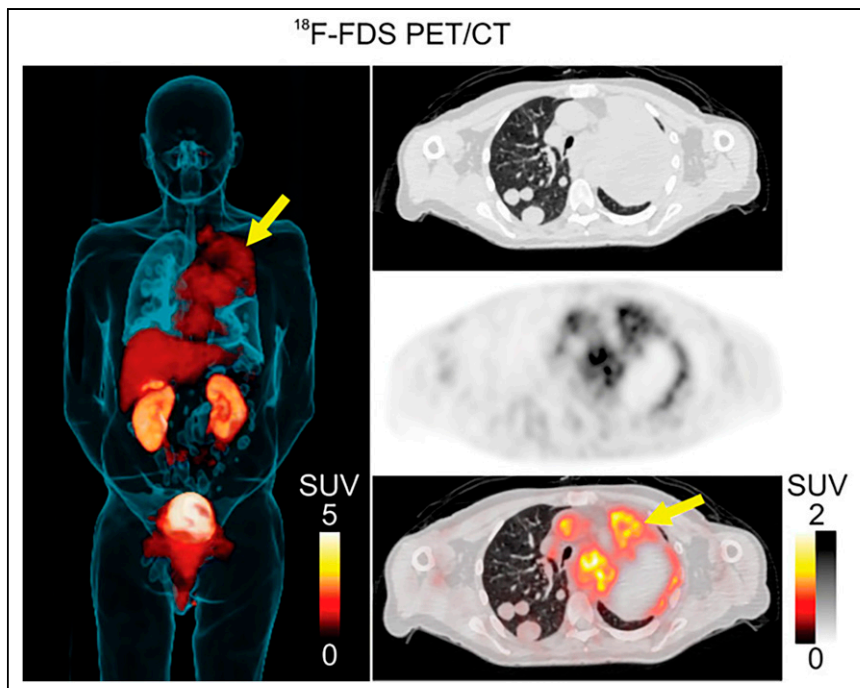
[^{18}F]FDS PET study of 67-y-old man with squamous cell carcinoma of lung and *K. pneumoniae* pneumonia. On left, 3-dimensional minimum-intensity projection is shown, with arrow indicating [^{18}F]FDS signal in infected tissues. On right, transverse CT, PET, and PET/CT images (from top to bottom) indicate minimal [^{18}F]FDS signal in right-sided cancerous lesions (arrow). (Adapted from (40).)
